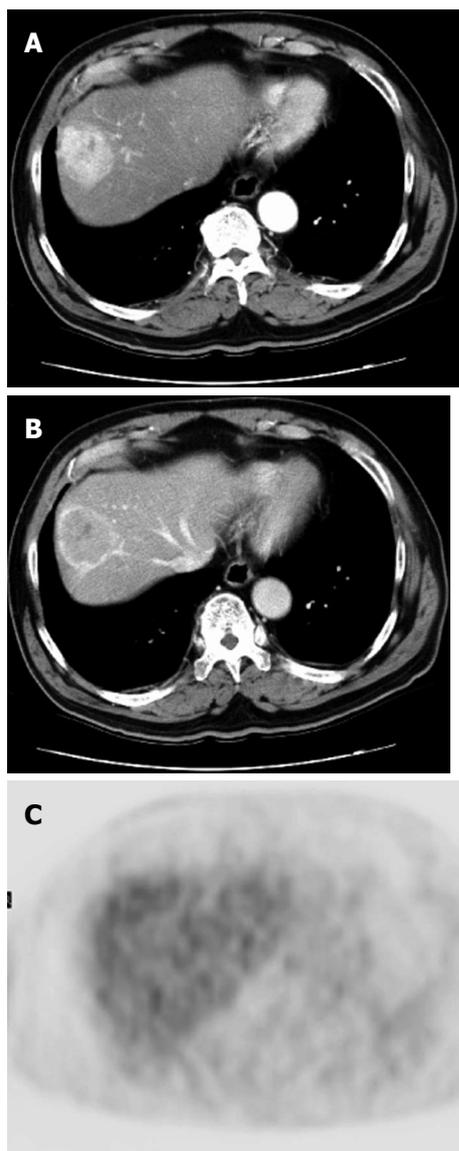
A case of well-differentiated hepatocellular carcinoma. A, B: Arterial and portal phase of dynamic computed tomography. Typical enhancement pattern of hepatocellular carcinoma is shown; C: FDG-PET. There is no fluorodeoxyglucose uptake.
